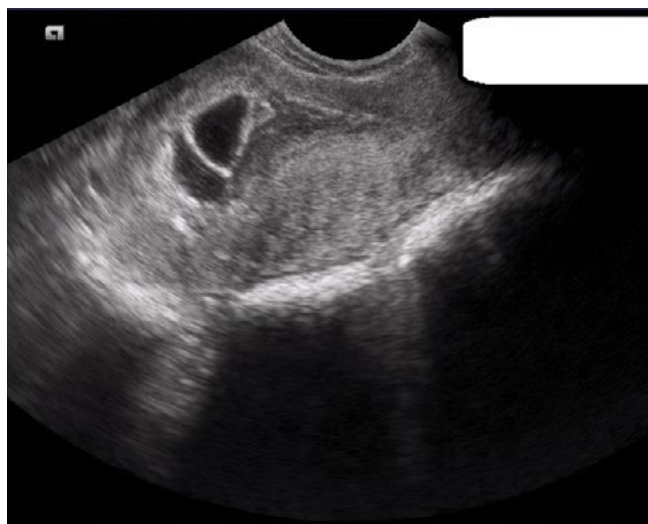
Gray scale TVS (Trans-vaginal sonography) image of a patient presenting with pain lower abdomen and vaginal bleeding at 5 wk 2 days. (Video clip shows the corresponding power Doppler tracing)
